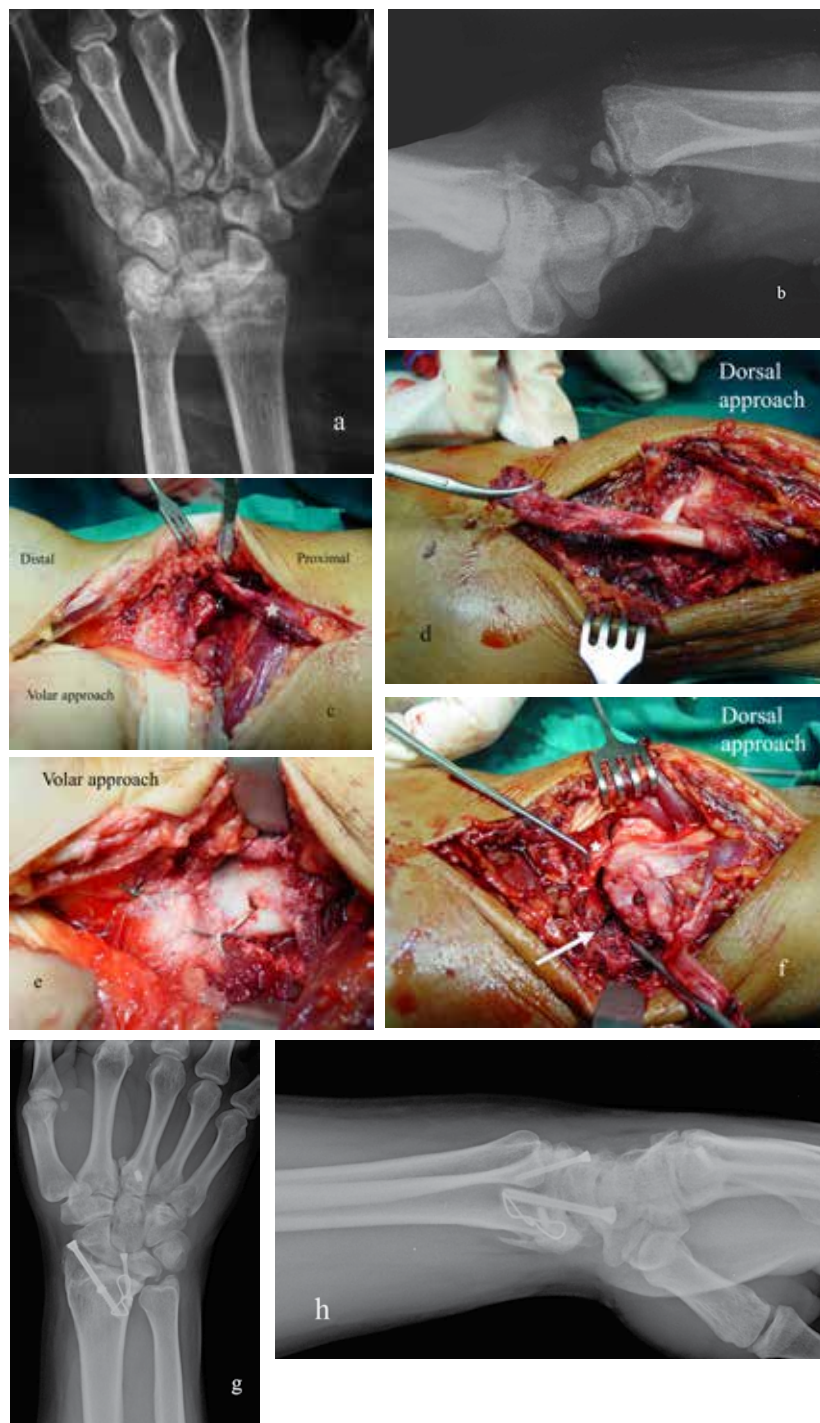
(a-h). Volar RC fracture-dislocation associated with comminuted fracture of third metacarpal base (a, b); With volar approach, over pronator quadratus, a tendon stump was found (asterisk) (c); With dorsal approach it appeared to be the avulsed insertion of the ECRB from the base of the third metacarpal, a finding indicative of the magnitude of rotational force applied (d); The volar radial rim was divided into two parts, a smaller radial bone fragment containing RC ligaments and a larger one concerning the ulnovolar fragment which were fixated with a bone anchor and a figure-of-eight wire frame respectively (e); Despite volar direction of the dislocation the dorsal radial rim was separated in 2 fragments: a dorsoulnar (asterisk) and a dorsoradial fragment (arrow) which were fixed with 2 cannulated screws (f); Final x-rays 5 years post-injury (g, h)
